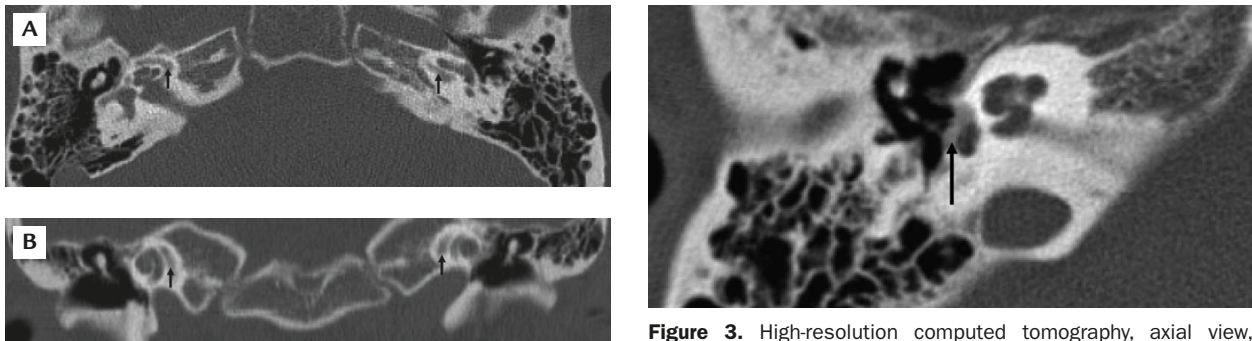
High-resolution computed tomography of a 28-year-old woman who underwent surgery for right otosclerosis: (A) axial view; (B) coronal view. The black arrows indicate pericochlear lucency on both sides.
